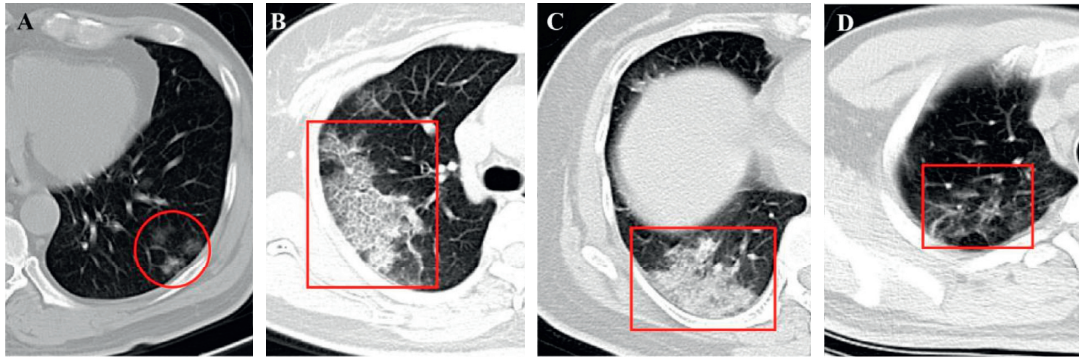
(a) A 46-year-old male COVID-19 patient with no obvious symptoms. CT scan shows three GGOs in the left lower lobe (red cycle). (b) A 46-year-old female COVID-19 patient with fever for 1 day. CT scan demonstrates crazy-paving pattern in the right upper lobe (red rectangle) (5 days after the onset of initial symptoms). (c) The same patient in (b) and the follow-up CT shows the consolidation in the right lower lobe (red rectangle) (8 days after the onset of initial symptoms). (d) A 38-year-old male COVID-19 patient with initial symptoms of dry cough and fatigue for 10+ days. CT scan shows the interlobular septal thickening in the right lower lobe (red rectangle) (7 days after the onset of initial symptoms).
